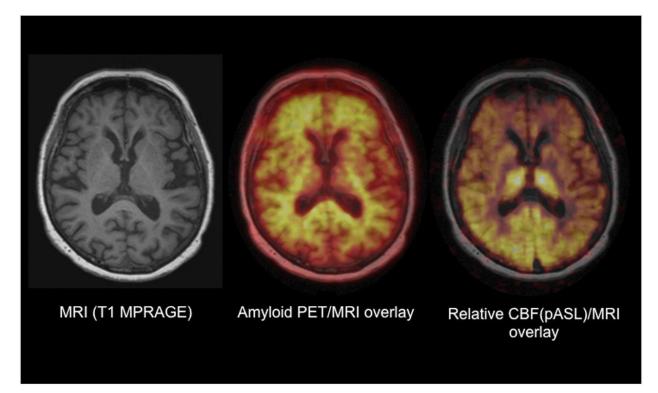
Simultaneous PET/MRI in dementia using ¹⁸F-florbetaben PET and pulsed arterial spin labeling (pASL) MRI. Reprinted with permission (*33*).
